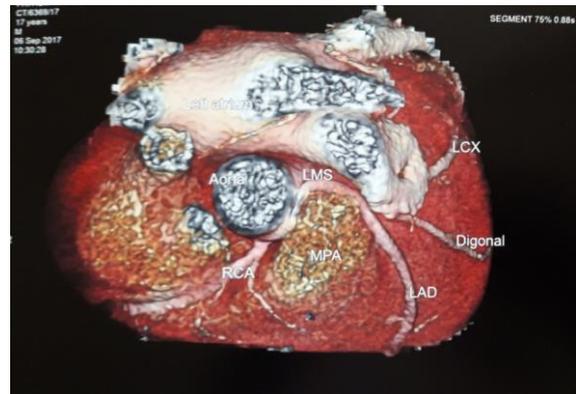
CT coronary angiogram (3D reconstruction)
